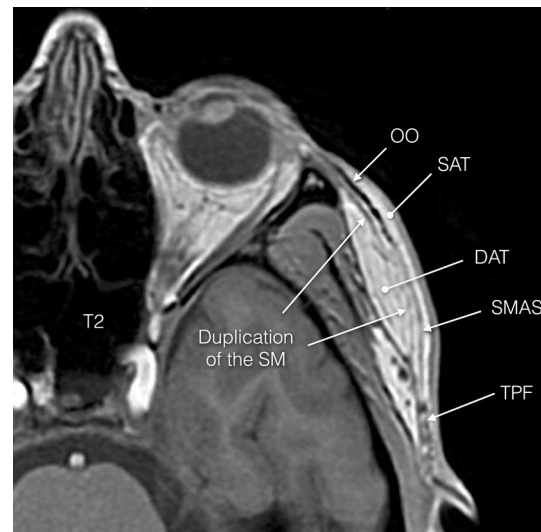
MRI scan in axial plane of subject #1 at the level of the caudal temporal region showing the multi-stratigraphic pattern observed in the face. *OO* orbicularis oculi, *TPF* temporo-parietal fascia, *SAT* superficial adipose tissue, *DAT* deep adipose tissue, *SM* stratum membranousum, *SMAS* superficial musculo-aponeurotic system
